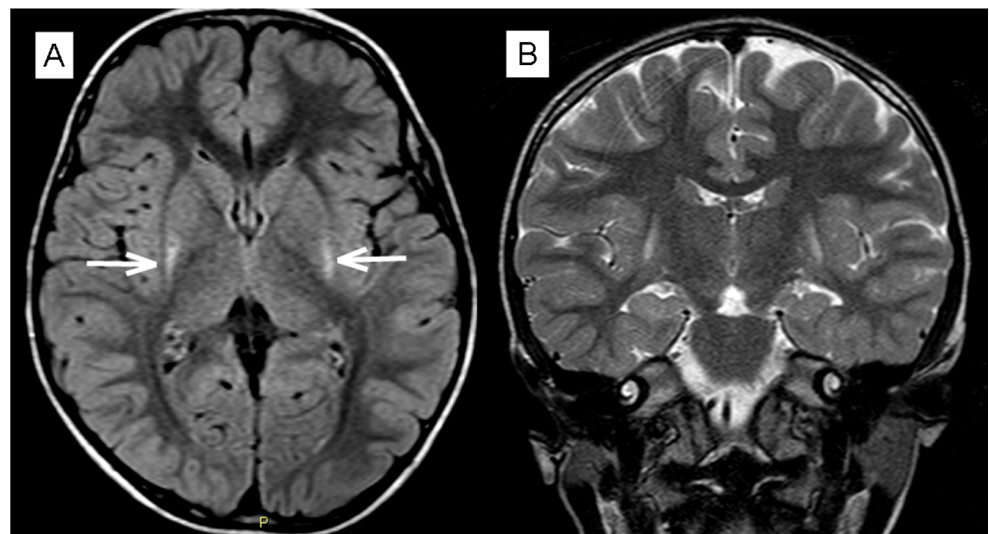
MR imaging of patient #11, aged 6 months at the time of imaging. Axial T2-weighted sequence through basal ganglia: bilateral hypersignal of the putamen (arrows)
